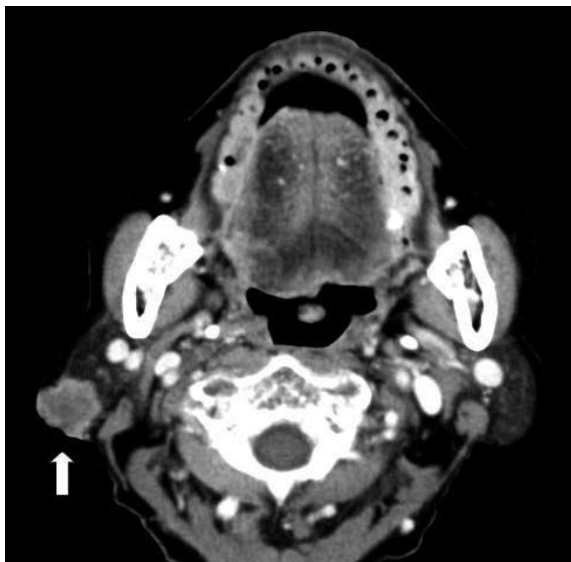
Head and neck computed tomography image showing invasion of the superficial lobe of the right parotid gland by the mass (white arrow) with subcutaneous fat layer extension.
